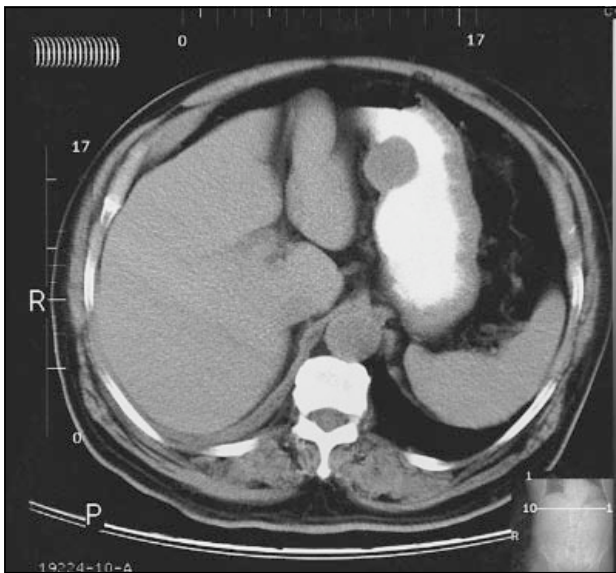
Intraluminal gastric stromal tumour. CT abdomen with oral contrast shows a small (2 cm) intraluminal, rounded tumour with a broad base and a smooth convex margin.
